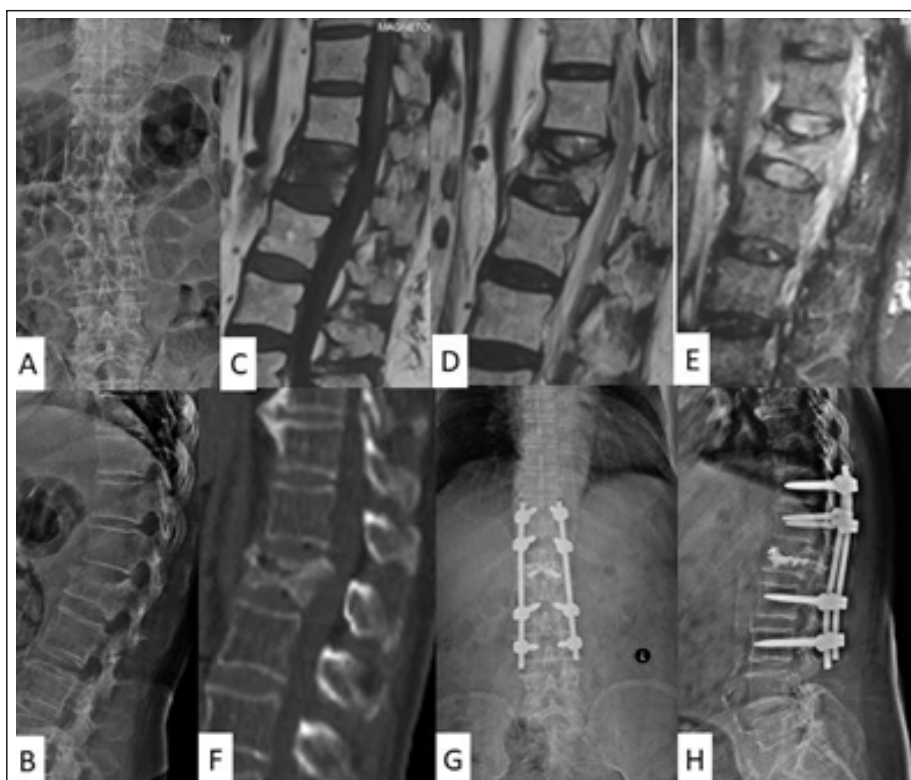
(a and b) Plain antero-posterior and lateral radiographs showing bow-string type of osteoporotic vertebral fragility fractures of L1 vertebra, (c and d) mid-sagittal T1-, T2-WI showing fractures of both superior and inferior endplates with diffuse edema of vertebral body, (e) mid-sagittal short tau inversion recovery image showing fractures of both superior and inferior endplates with diffuse edema of vertebral body and hypointense (black line) near the superior end plate (which is a poor prognostic factor for fracture healing, (f) mid-sagittal compute tomography section showing pseudoarthrosis at 5 weeks post-injury, (g and h) plain post-operative antero-posterior and lateral radiographs showing T11 to L3 posterior instrumented stabilization and L1 vertebroplasty and L1 laminectomy (as the patient presented with neurological deterioration).
